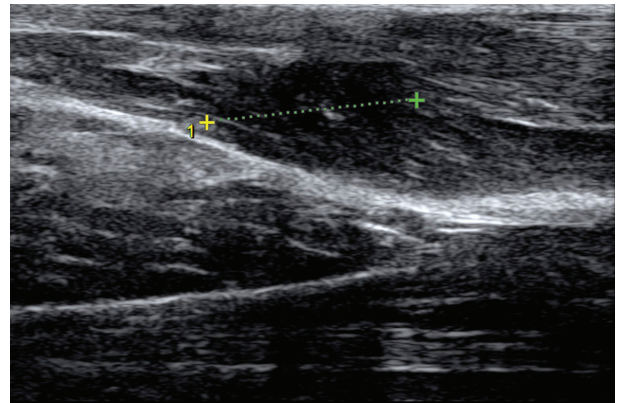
Ultrasound image revealing minimal reaction of edematous type of the extensors of the periskel-etal muscle sleeve
